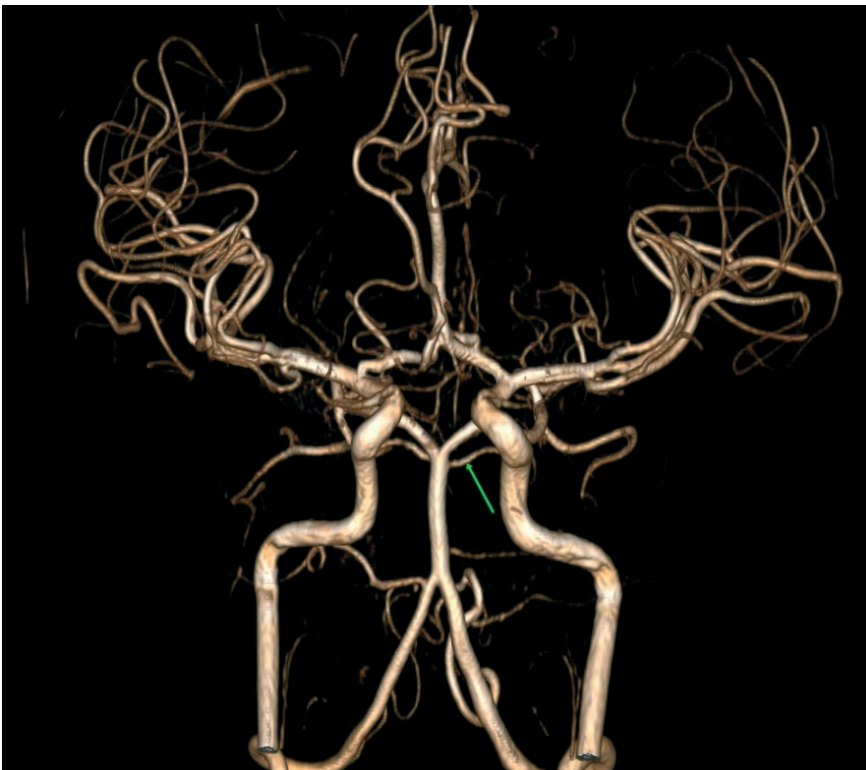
Magnetic resonance imaging image
